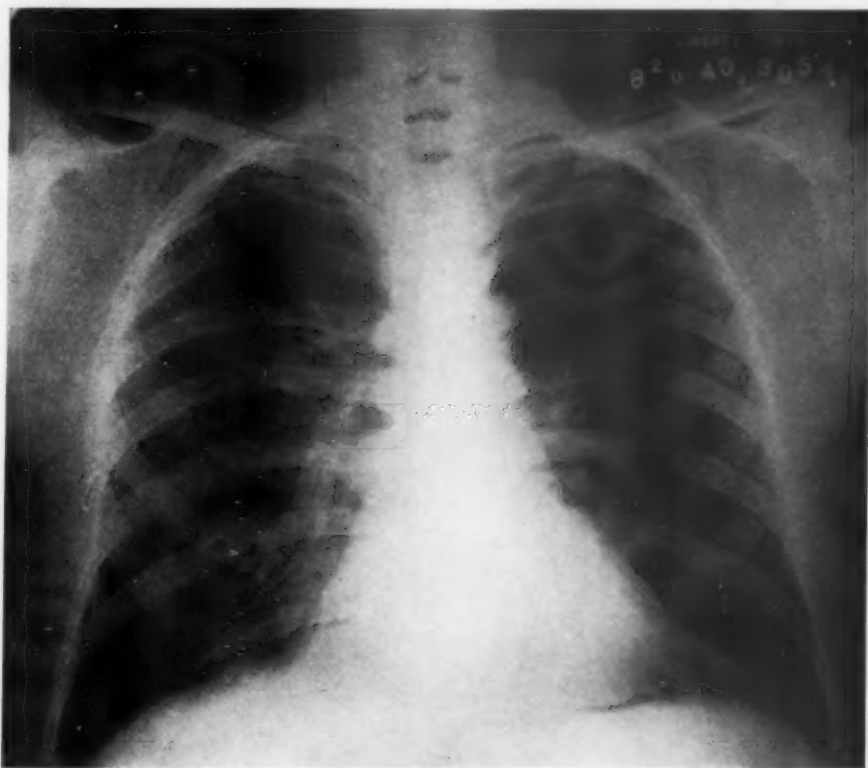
(Case 4.) Roentgenogram taken August 20, 1940. Almost complete clearing of the infiltration in the right lung; no evidence of rarefaction.
